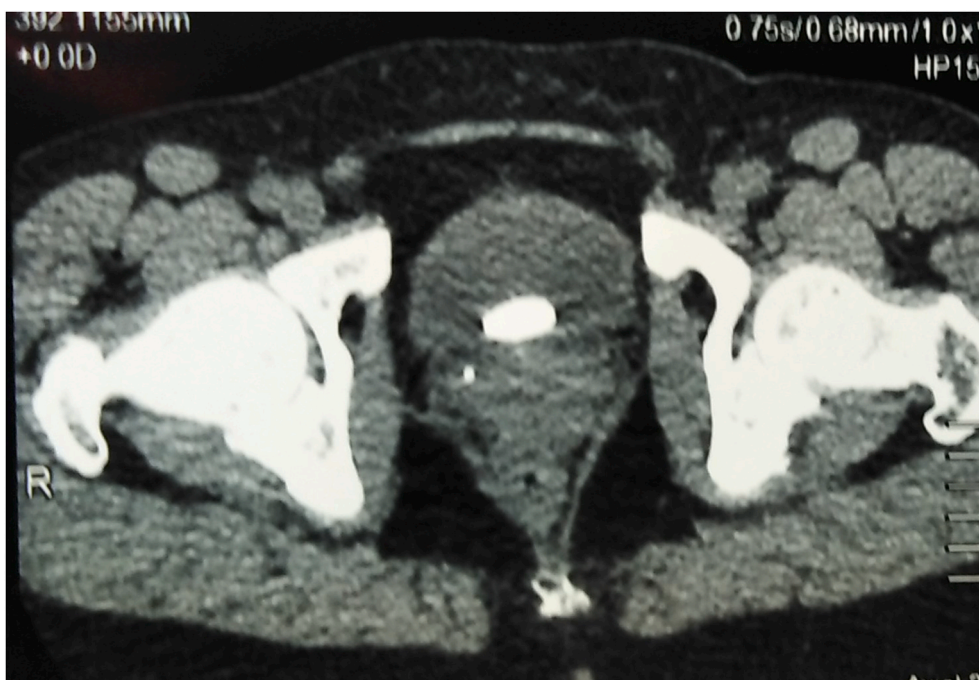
Abdominopelvic CT scan showing the IUD.
